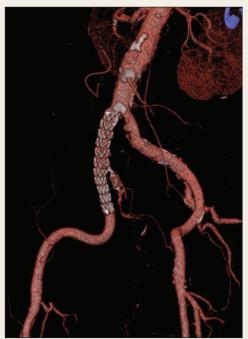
Postoperative three-dimensional CT reconstruction with volume rendering demonstrated placement of the INCRAFT® Stent Graft, a patent limb, and sac thrombosis. Note the Amplatzer occlusion plug at the origin of the internal iliac artery.
